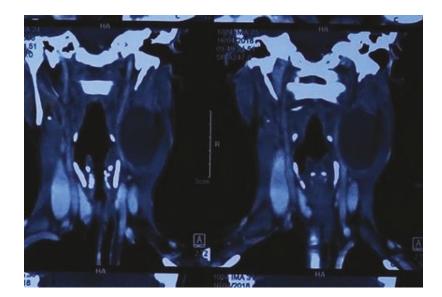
Contrastenhanced CT scan coronal section showing a homogenous hypodense lesion
